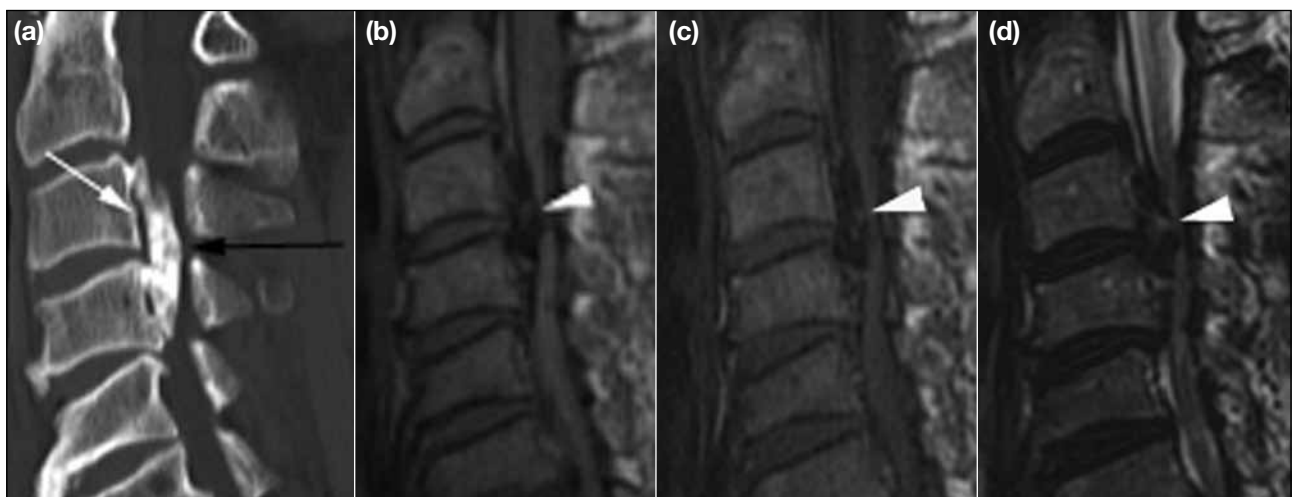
The same 57-year-old male positively identified on initial magnetic resonance (MR) with confirmatory computed tomography (CT). (a) Sagittally reconstructed CT shows thickened and continuous ossification of the posterior longitudinal ligament (OPLL; black arrow) with characteristic sharp and thin radiolucent line separating the ossified posterior longitudinal ligament from the posterior vertebral margin (white arrow). (b) Proton density, (c) T1-weighted and (d) T2-weighted sagittal images of the same patient. Note the small focus of high signal within the OPLL at the level of C3/4 which could represent fatty marrow signal (white arrowheads).
